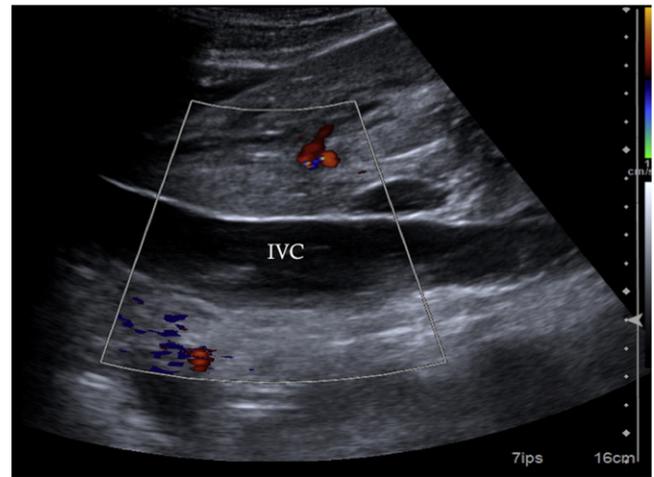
Immediate postoperative abdominal Doppler ultrasound. Color Doppler ultrasound confirming the interruption of the blood flow in the enlarged inferior vena cava (IVC).
